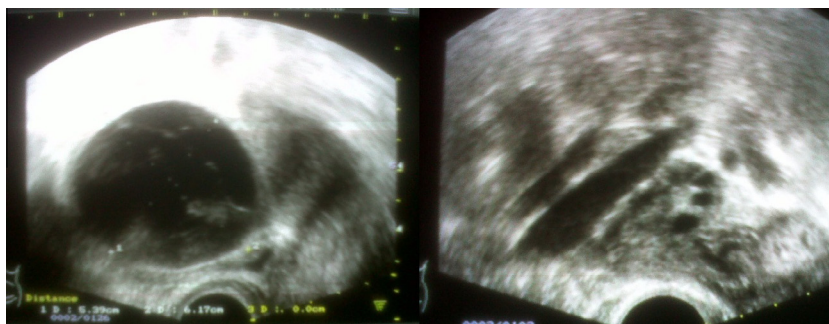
Ultrasound showing left ovarian cyst (left) and normal right ovary (right).
